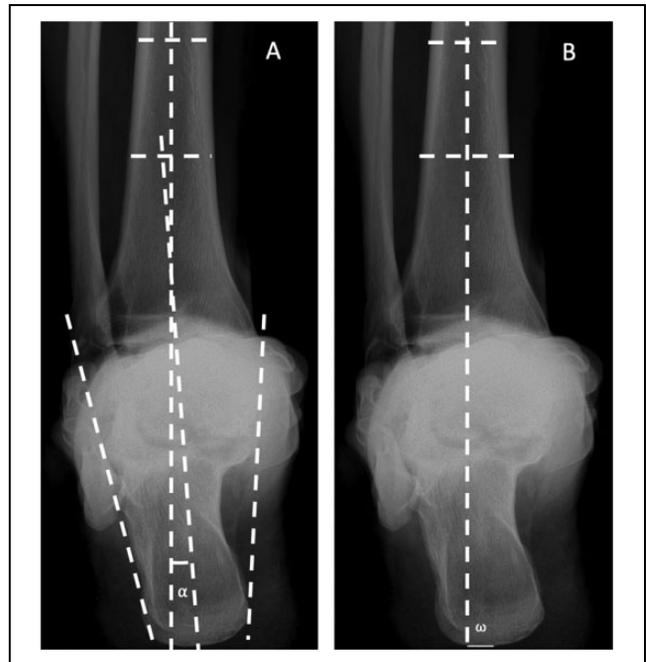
Examples of radiographic hindfoot alignment measurements without Coleman block. (A) Hindfoot alignment angle (HAA) represented by angle α , (B) hindfoot moment arm (HMA) represented by ω .
